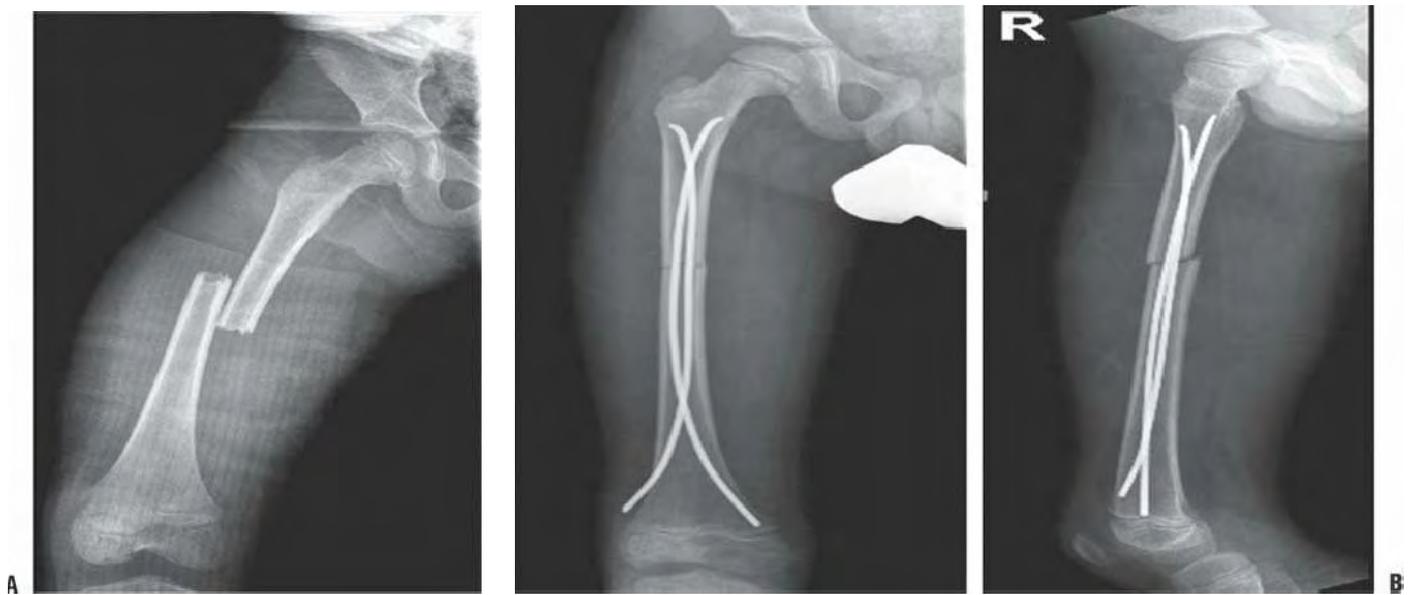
A: A transverse diaphyseal stable femur fracture in a 7-year-old. This is an ideal fracture and age for elastic intramedullary nail fixation B: Postoperative radiographs after stabilization with titanium elastic nails.
